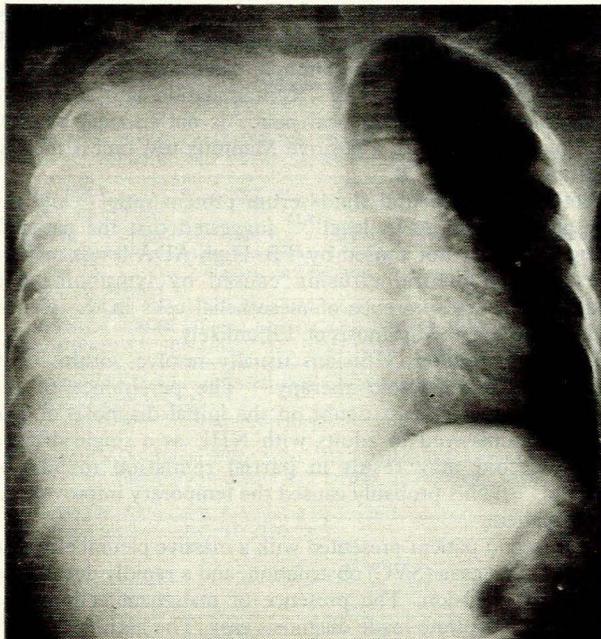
Case 2. Chest radiograph showing left-sided pleural effusion and mediastinal shift.
